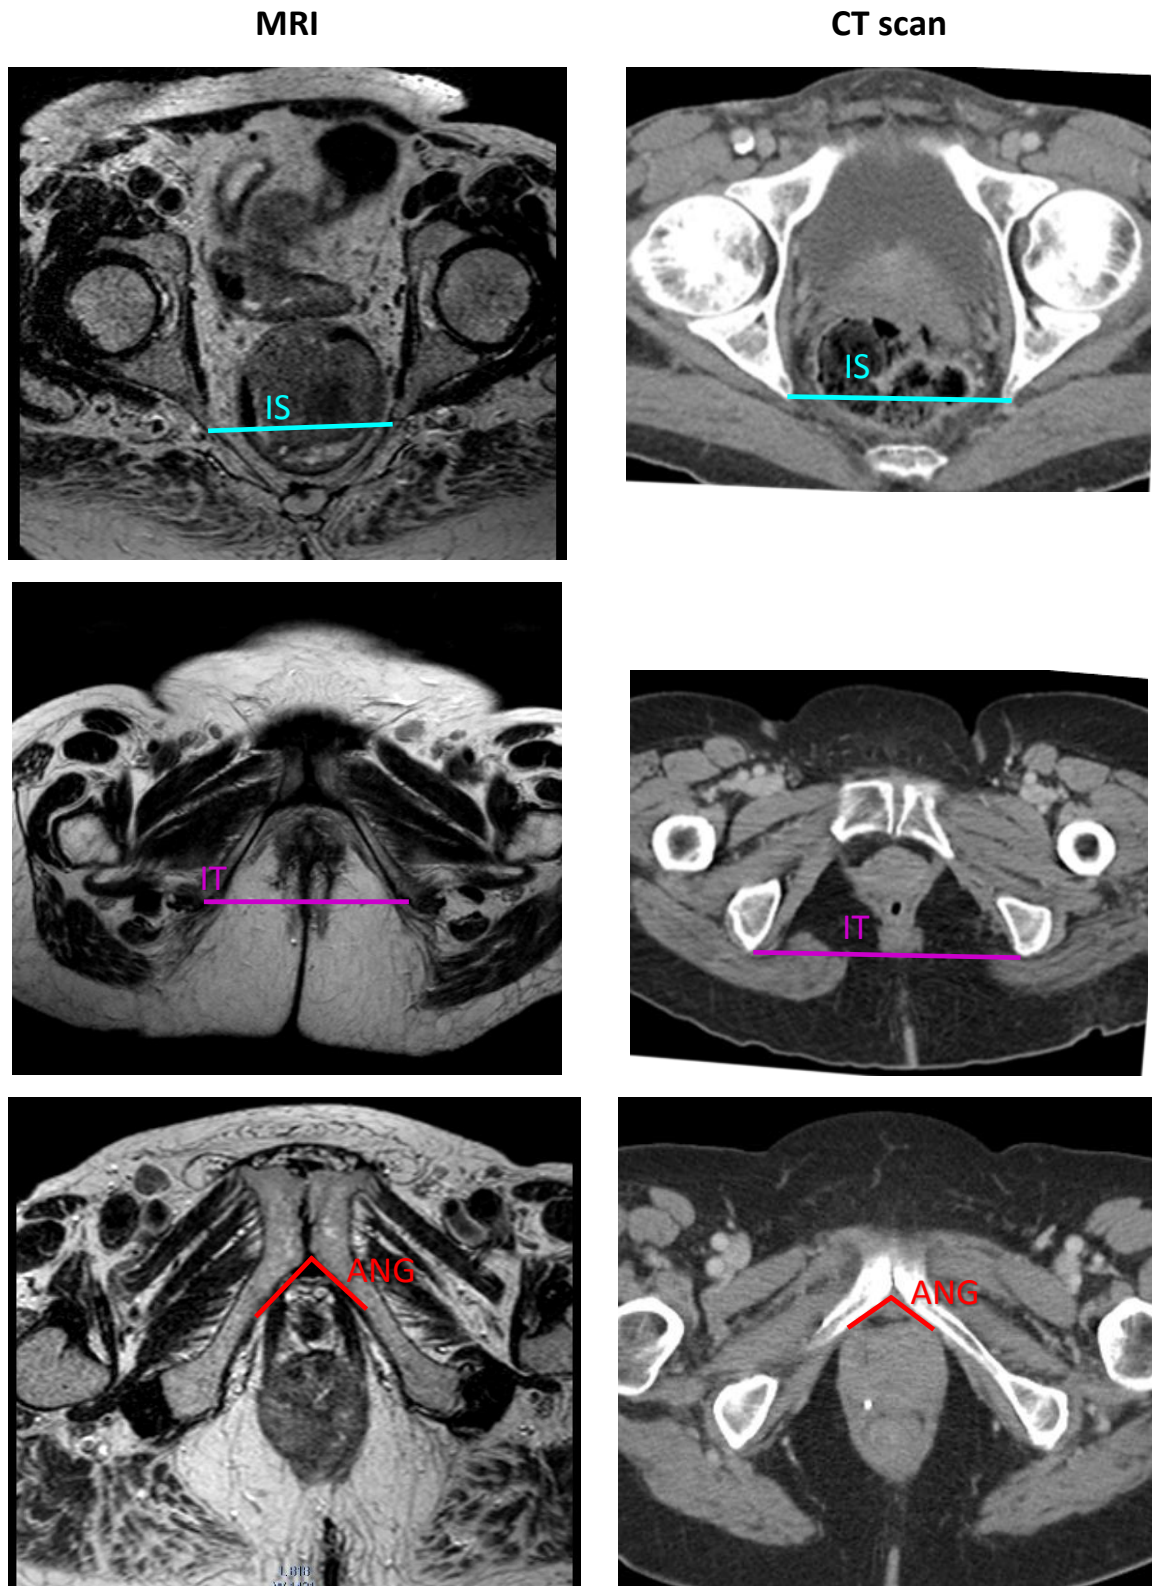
Comparison of MRI (left) and CT scan (right) measurements (different subjects)
